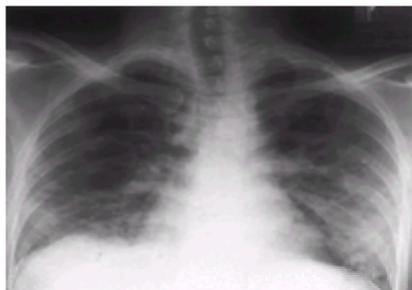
Typical radiographic appearance of PCP, with diffuse granular opacifications.
